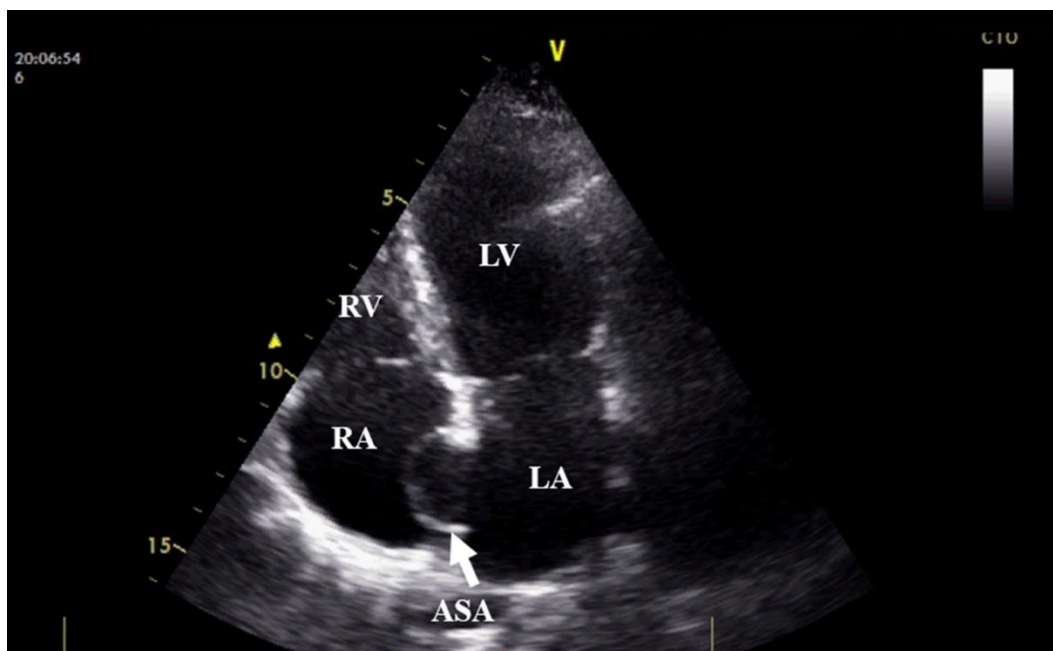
Transthoracic echocardiography in apical four chamber view showing atrial septal aneurysm with left to right displacement. ASA, atrial septal aneurysm; LA, left atrium; LV, left ventricle; RA, right atrium; RV, right ventricle
